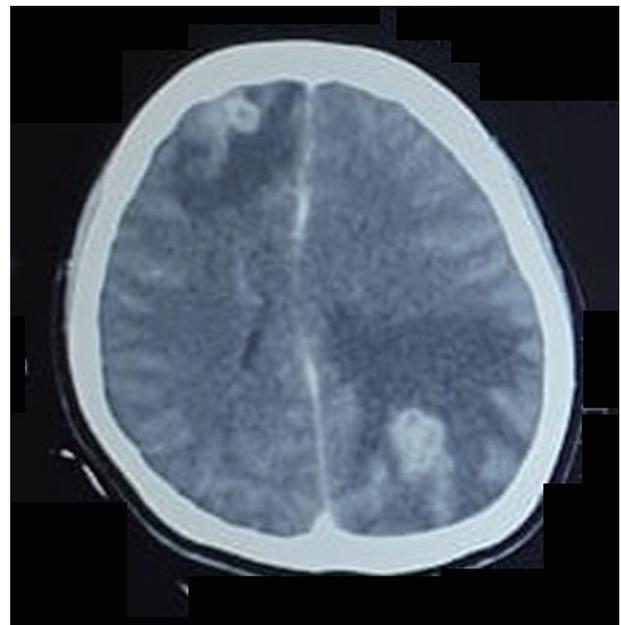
Contrast-enhanced head CT imaging showing multiple intracerebral tuberculoma.
